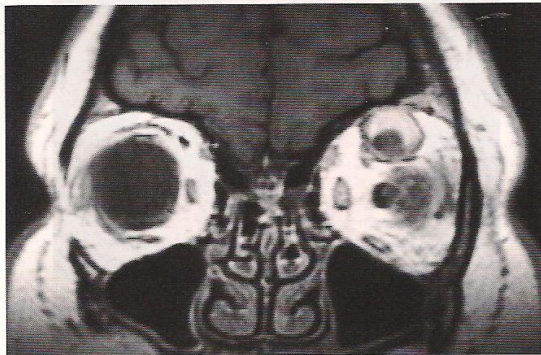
Coronal magnetic resonance imaging in T1-weighted image showing the superior orbital mass with low-signal component.
